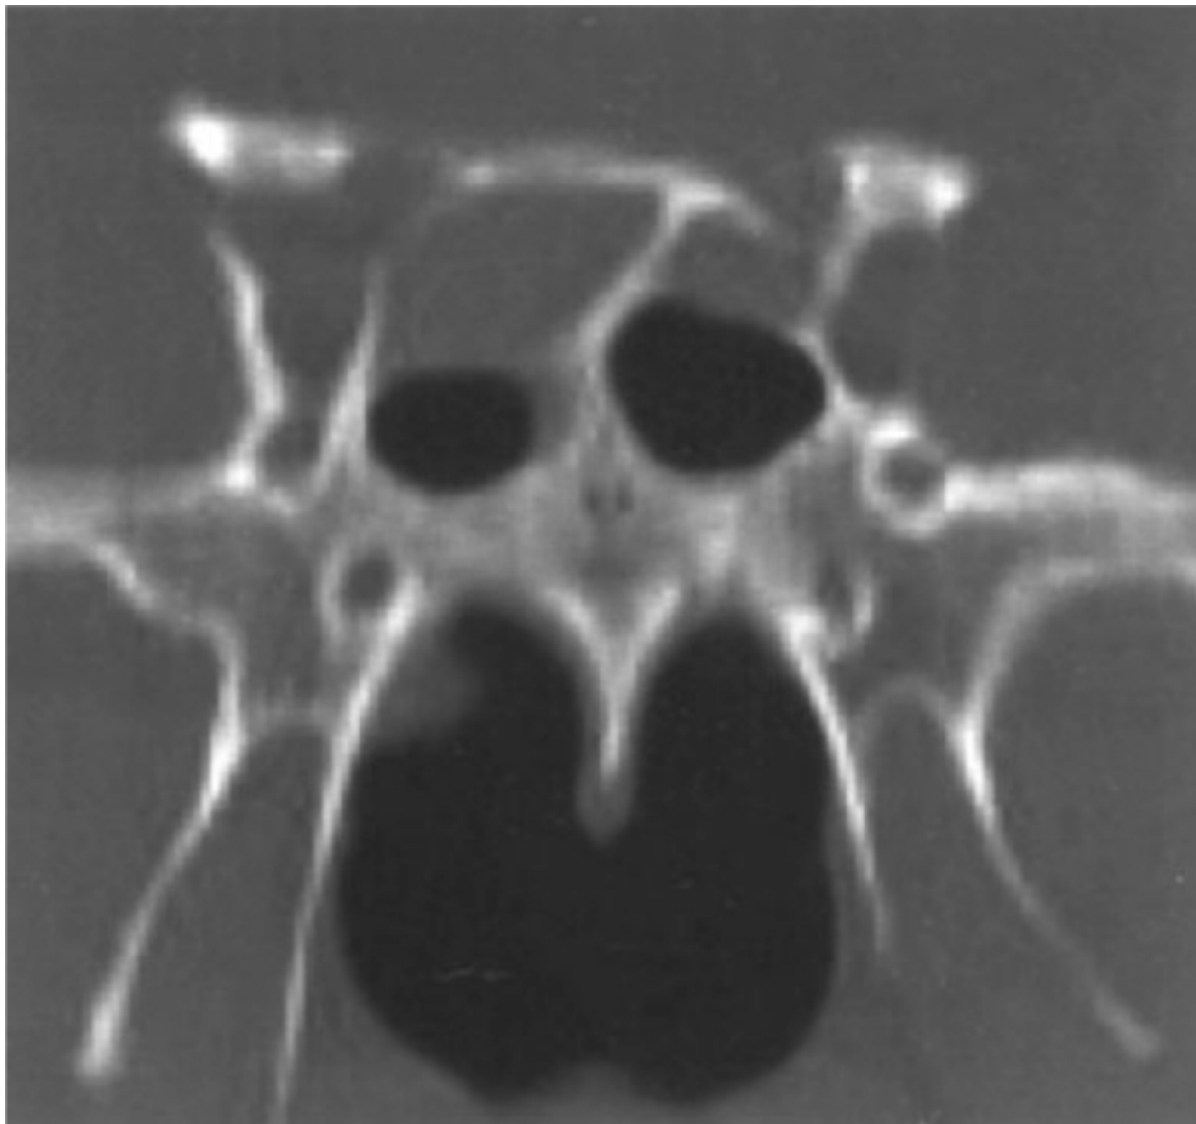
Coronal computed tomography scan demonstrating bilateral Onodi cells, also known as *posterior ethmoid cells*, which override the sphenoid sinus. In this case, the sphenoid sinuses are clear and the Onodi cells are opacified.
